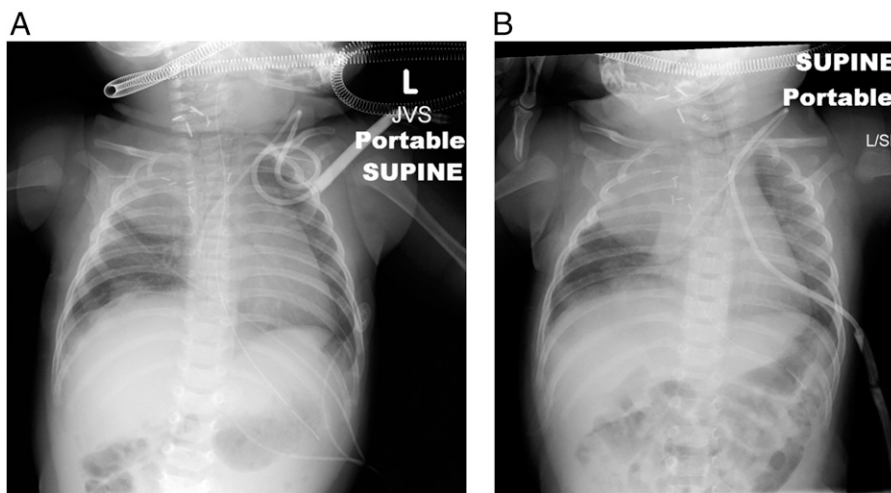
A. Radiograph after 2 courses of clofarabine shows a stable right upper lobe opacity of unclear etiology without mediastinal shift. B. Two weeks later, radiograph after a third course of clofarabine shows enlargement of the right upper lobe opacity with mediastinal shift.
